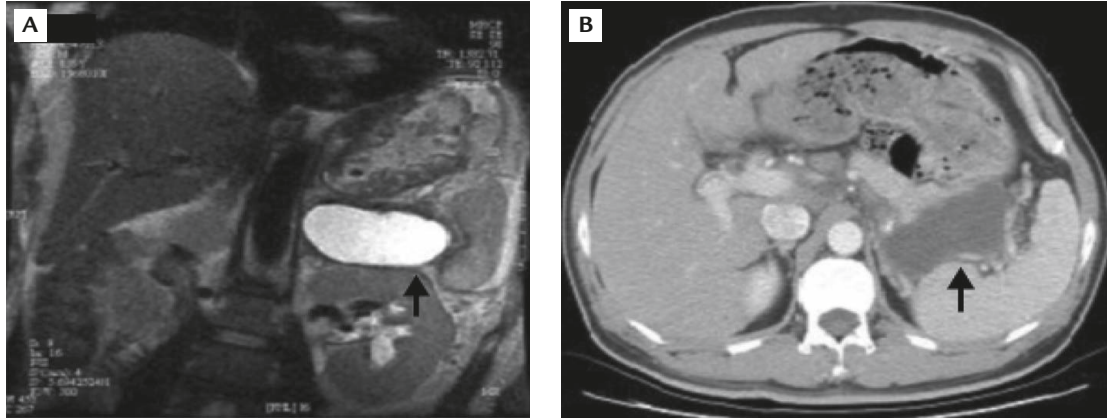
(A) Magnetic resonance imaging and (B) computed tomography of the abdomen revealed pancreatitis with regional edematous change and a cystic lesion measuring 8.8×4.8 cm in size at the pancreatic tail.
